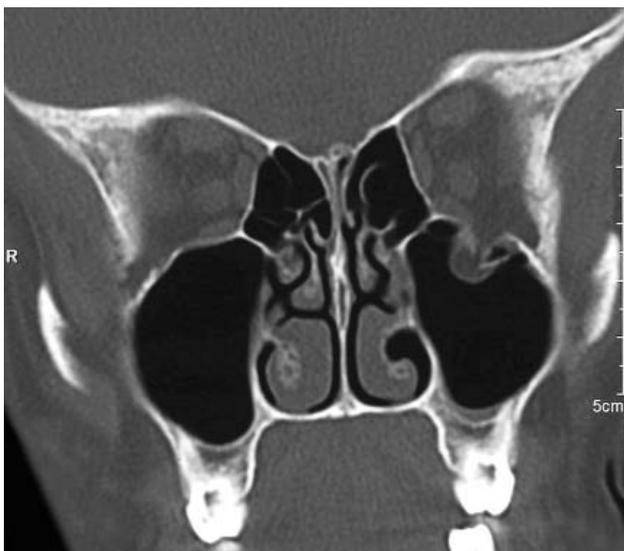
Preoperative coronal CT scan showing fractured orbital floor and herniated orbital contents.
